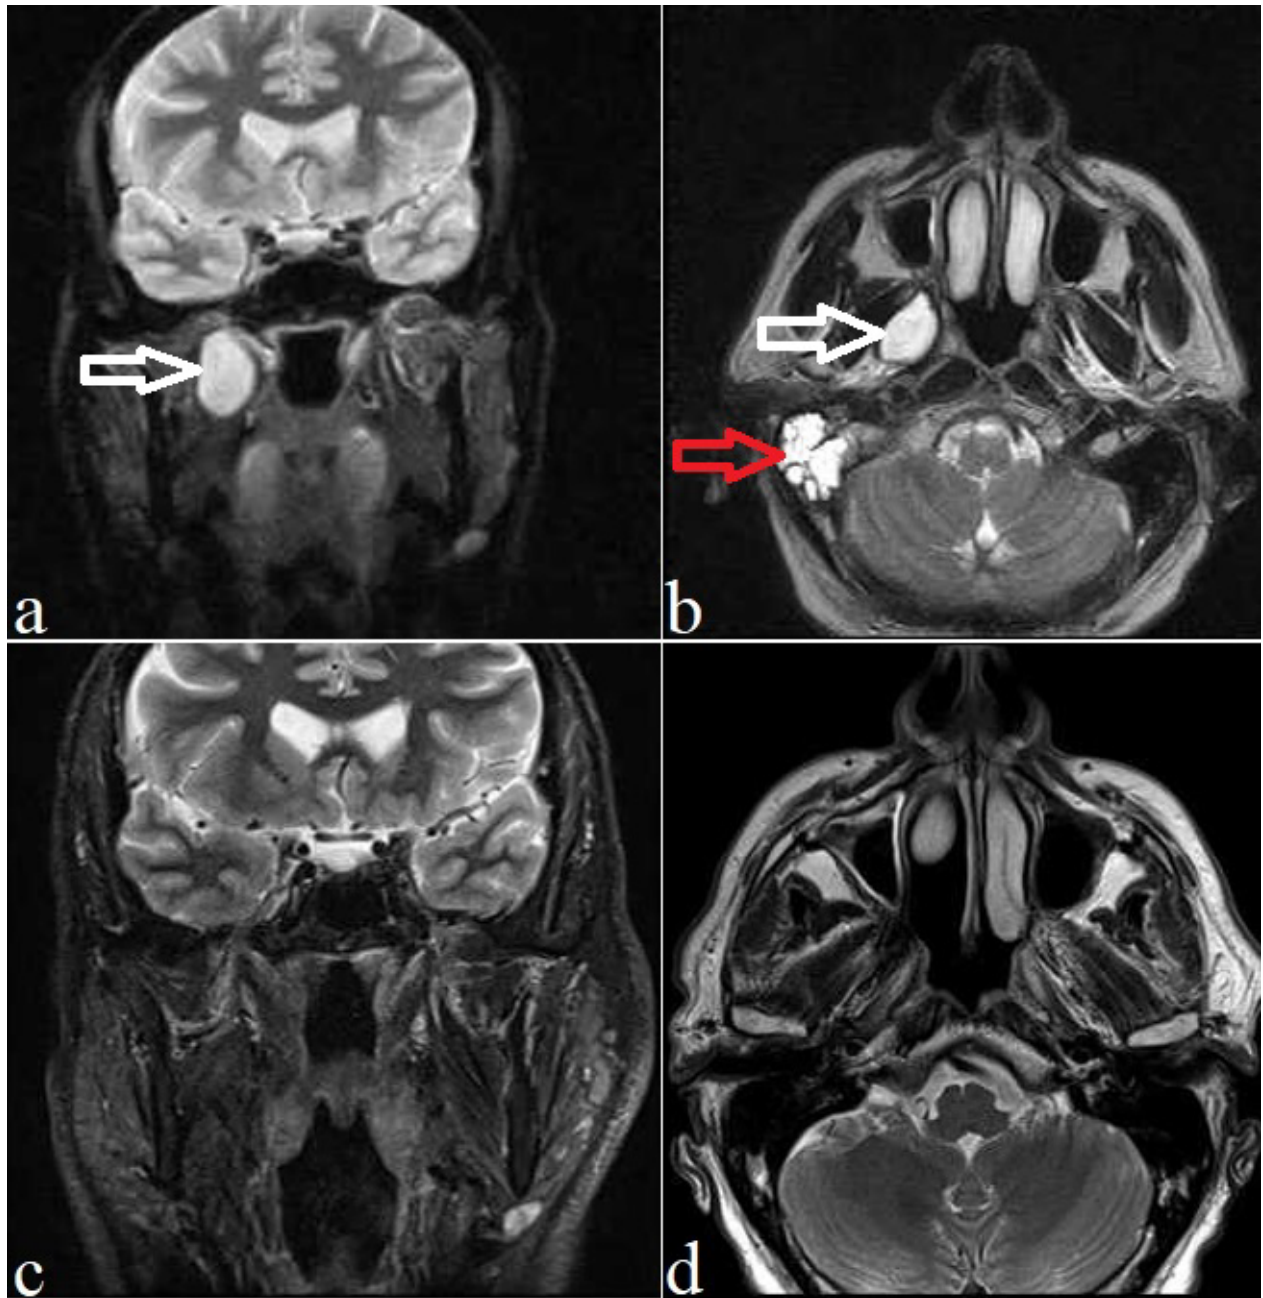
Preoperative a) coronal and b) axial T2-weighted MRI of the patient with Infratemporal fossa cavernous hemangioma which shows a well-defined border and high intensity (white arrow). It also demonstrates otomastoiditis due to serous otitis media (red arrow). Postoperative 1.5 years c) coronal and d) axial T2-weighted MRI of the patient. There was no evidence of recurrence of tumour and otomastoiditis.
